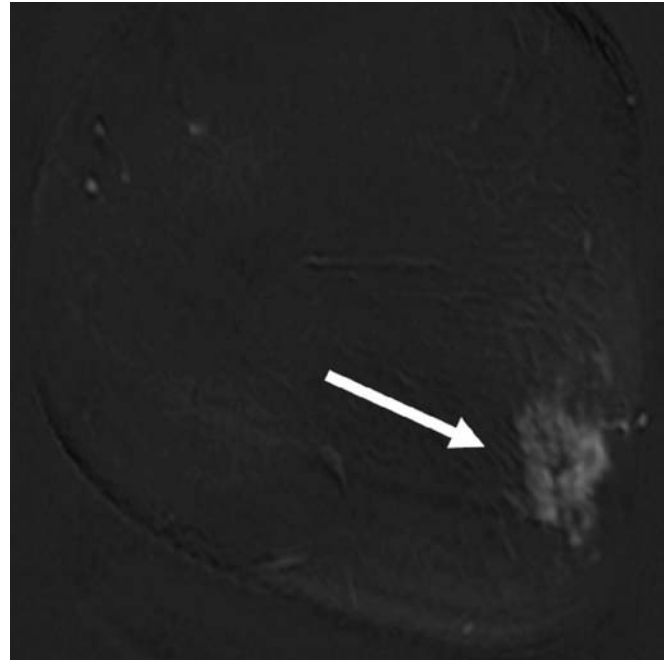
Atypical ductal hyperplasia. FLASH T1 enhanced MRI subtracted image shows clumped, non-mass-like enhancement in the upper-outer quadrant of the right breast (arrow). Stereotactically-guided vacuum assisted biopsy of powdery calcifications in the same area demonstrated atypical ductal hyperplasia. The diagnosis was confirmed at subsequent surgical excision.
